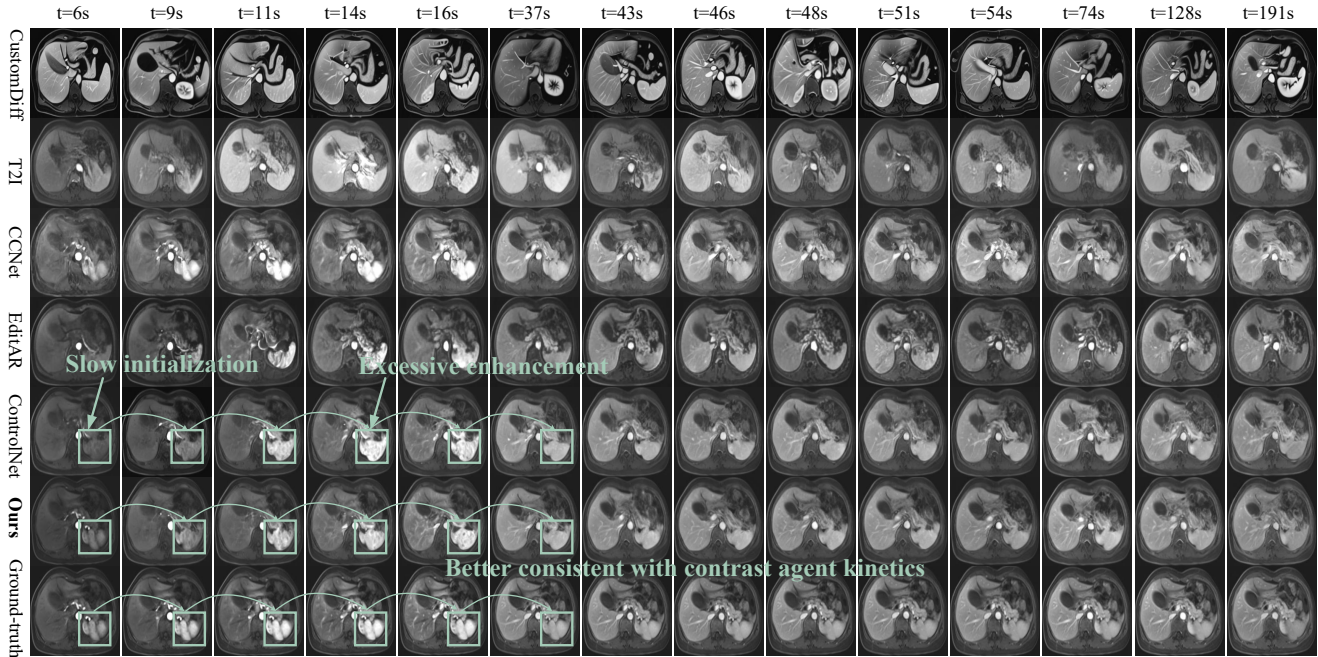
Visualization results of spleen in Abdominal DCE-MRI shows that our CEKWorld conforms to the spleen contrast agent kinetics, exhibiting the characteristics of rapid synchronous enhancement, progressive homogenization, and sustained homogeneous high signal. In contrast, methods such as ControlNet and CCNet have defects, including delayed start of enhancement, abnormal intensity, or content distortion.
